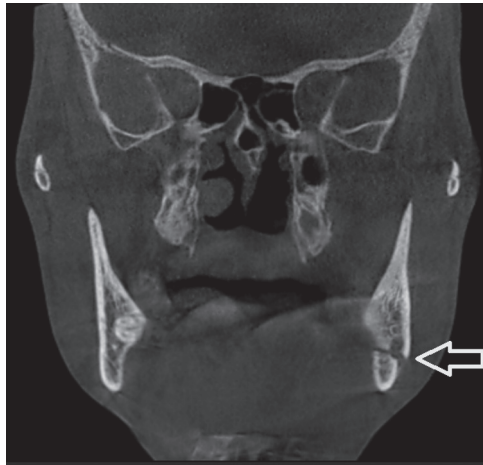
Left angulus mandible fracture on the coronal section of CBCT.
